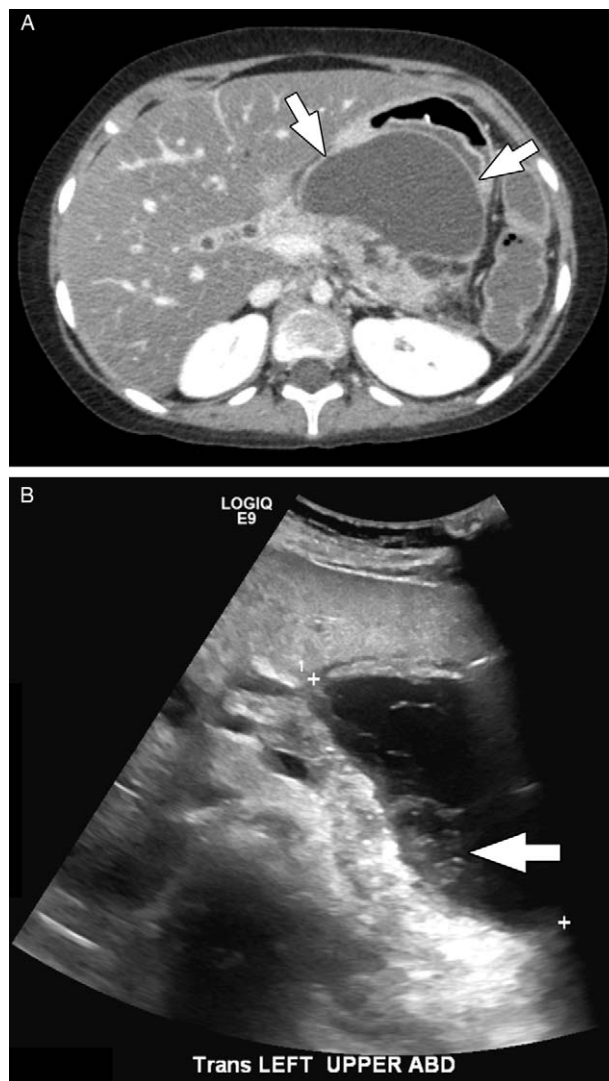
A 10-year-old girl with walled off pancreatic and peripancreatic necrosis. (A) Axial image from a CT performed with intravenous contrast material shows a walled off collection involving the body of the pancreas and the peripancreatic tissues in the lesser sac (arrows). Note how the content of the collection appears relatively simple by CT. (B) Transverse image from a transabdominal ultrasound performed the next day shows the same collection but with layering solid/semi-solid debris (arrow). CT = computed tomography.
